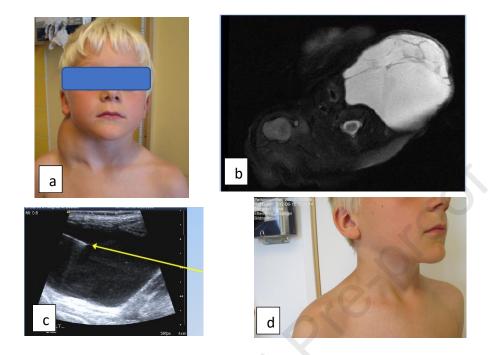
Macrocystic LM: a clinical feature, b T2-weighted MRI image of large fluid filled cysts, c Ultrasound guided puncture of cysts with injection of OK-432, d Clinical outcome after one sclerotherapy session.
